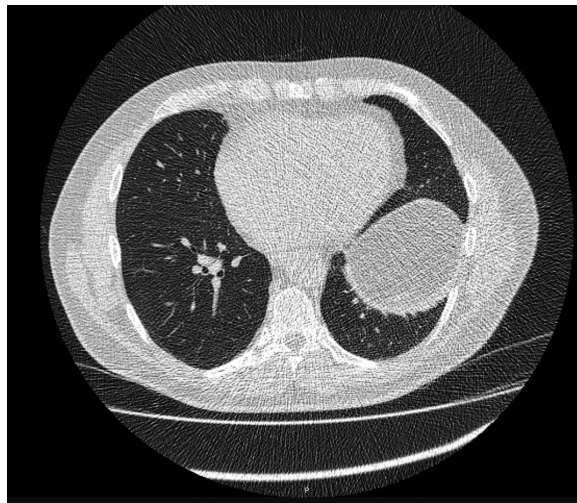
Computed tomography scan 6 months after initial presentation confirming the left hemidiaphragm.
